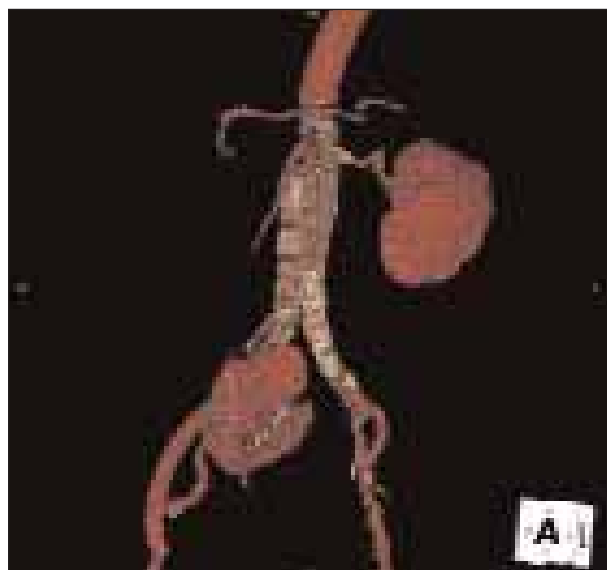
A postoperative CT scan of patient after aneurysmal exclusion with custom, branched graft.
